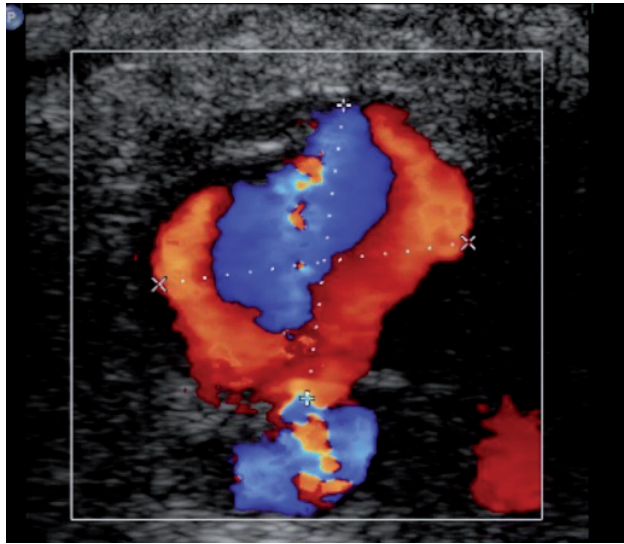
Color Doppler ultrasound image showing a transverse section of the pseudoaneurysm communicating below with the femoral artery.
